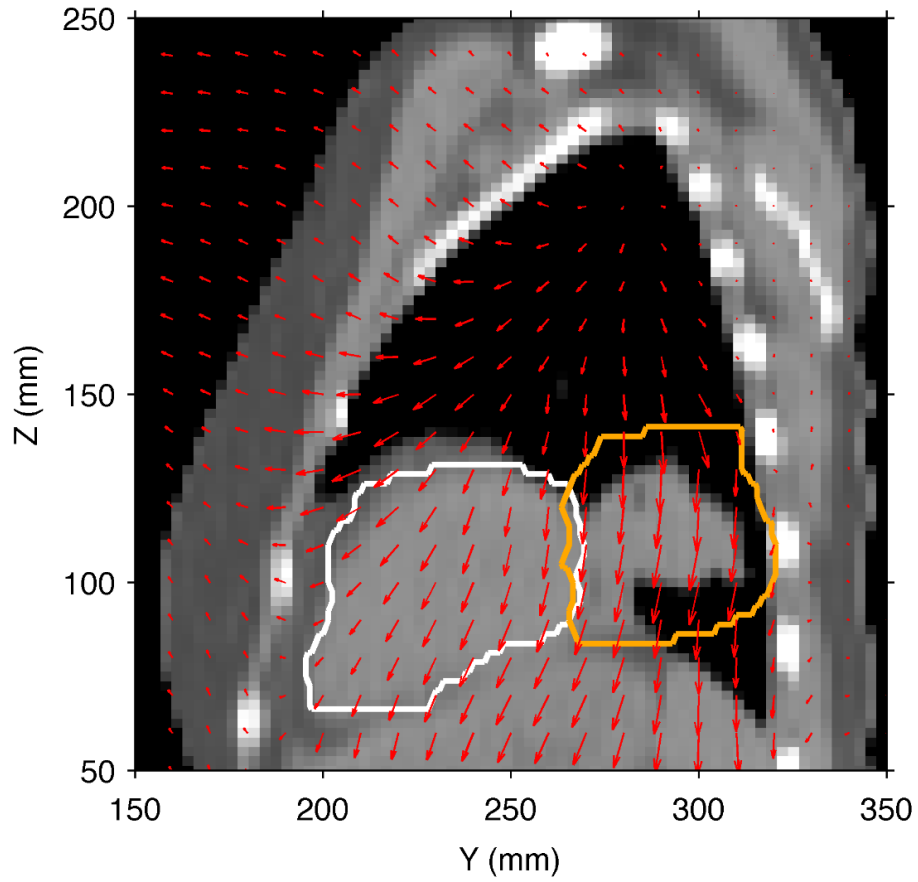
Sagittal CT slice for the lung cancer patient in the reference motion state at end-exhale. The CTV is indicated by the orange contour, and the heart contour is shown in white. The overlaid red vectors indicate the YZ components of the deformable image registration vectors and show the movement of tissue to a different motion state at full-inhale.
